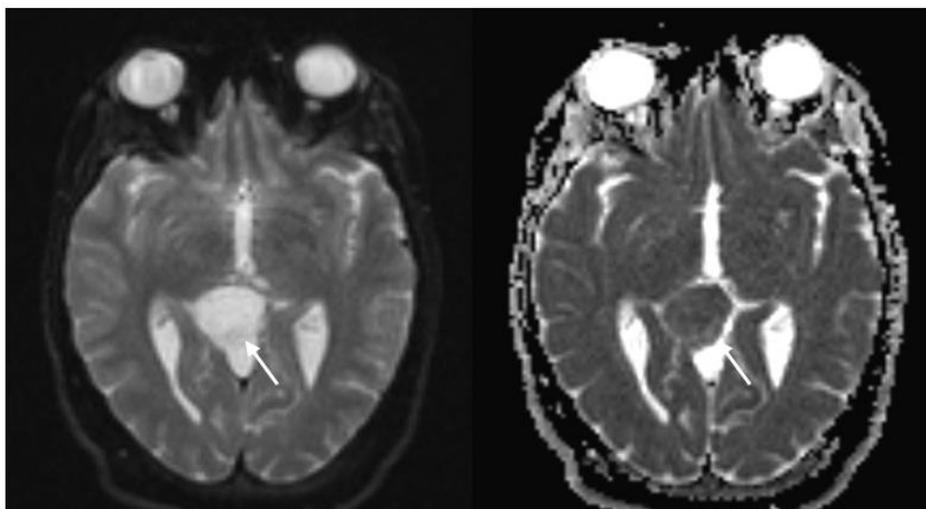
Diffusion MRI sequence: Hypersignal diffusion and with ADC restriction
